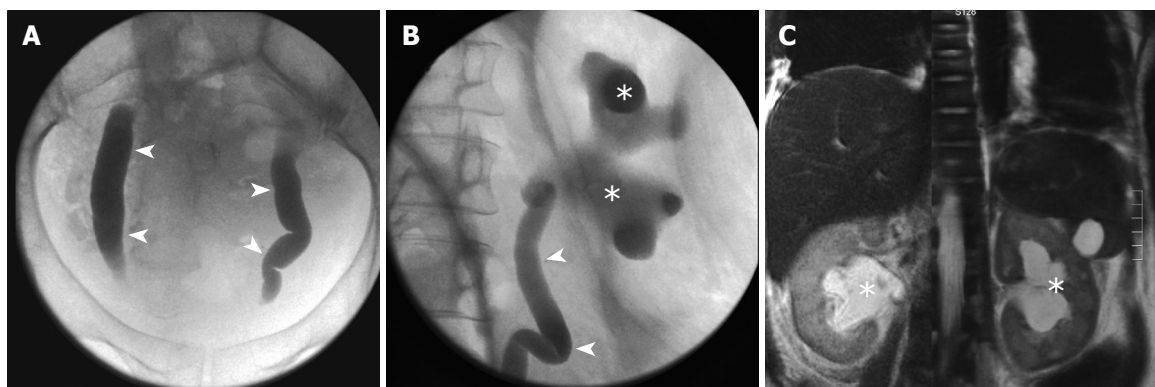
Hydronephrosis and megaureters: the presence of distended ureters (megaureters, arrowheads) was appreciated during a voiding nephro-uretero-cystogram (A, B) whereas hydronephrosis (stars) was detected by magnetic resonance imaging of the abdomen (C) as well as during the nephrogram (B).
